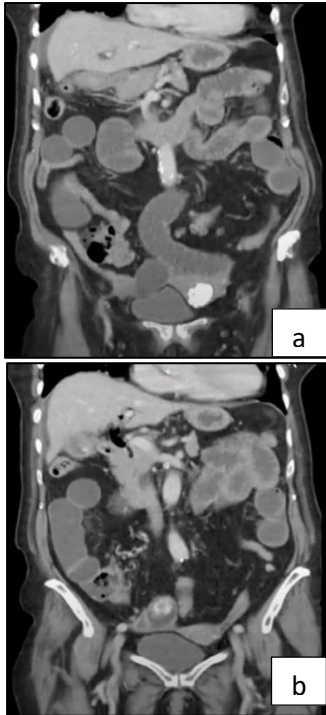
(a and b): Simple CT and abdomino-pelvic contrasted study. Gallbladder with 7 mm thickened wall with hyperdense images in its interior (onion layers) with intra and extra hepatic pneumobilia with dilatation of the biliary tract with dilatation of intestinal loops with a 27 mm gallbladder in terminal ileum.
